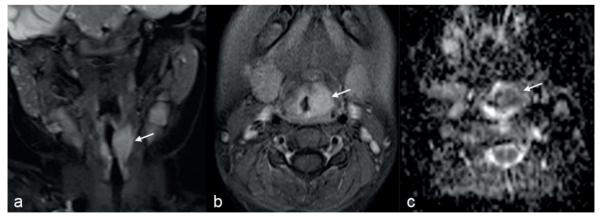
Magnetic resonance imaging of Case 1 at disease onset. (a) Coronal fat saturated T2-weighted images show the hyperintense soft tissue thickening at the left side of the supraglottic larynx. (b) Axial fat saturated post-contrast T1-weighted images show diffuse enhancement of the soft tissue thickening. (c) Apparent diffusion coefficient (ADC) map demonstrates restricted diffusion in the lesion.
